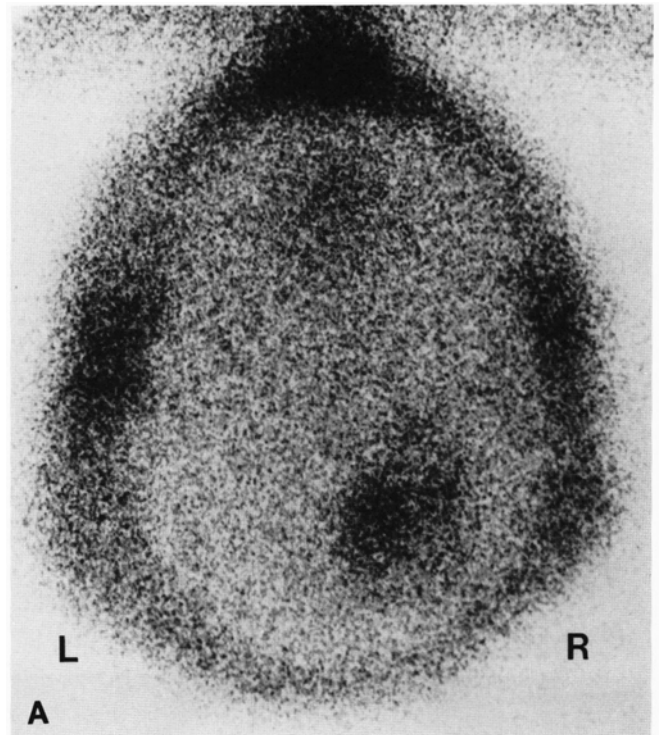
(A) Six month post-surgery ^{201}Tl scan showing increased uptake in the region of tumor recurrence. (B) Six month post-surgery CT scan demonstrates the site of tumor recurrence (arrow).
